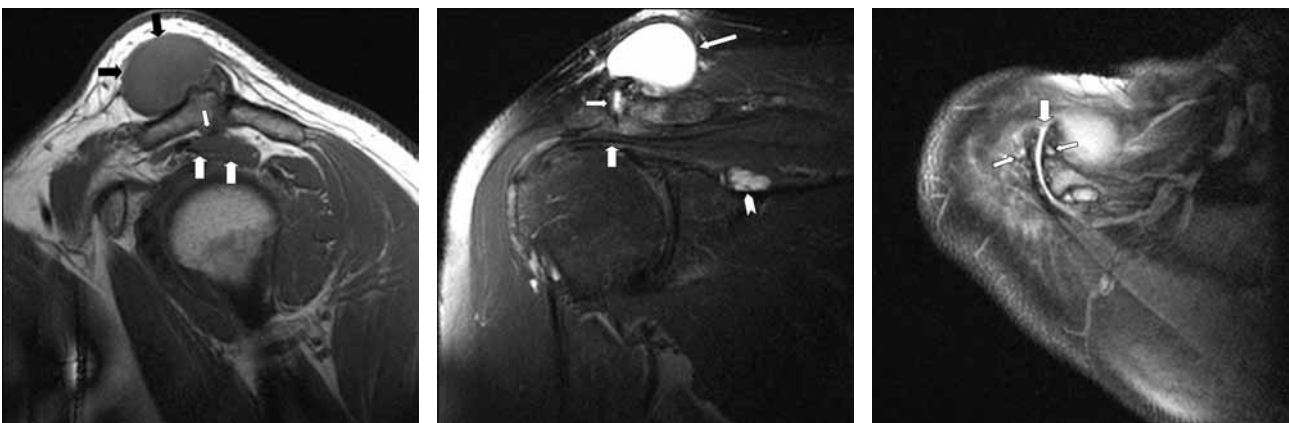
MR imaging of the right shoulder.
